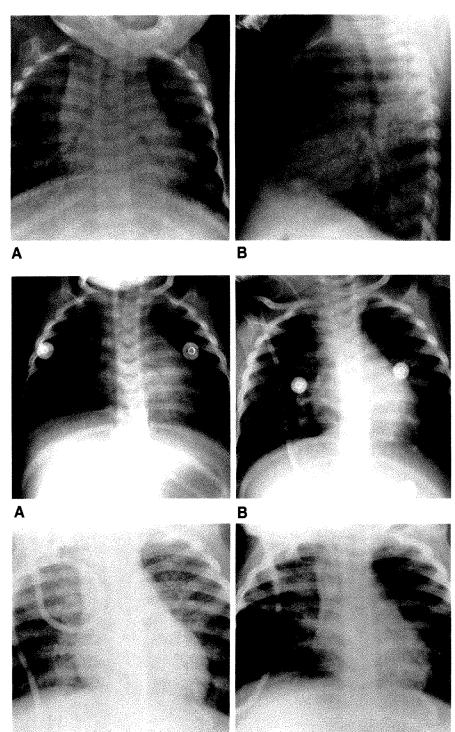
Evolution of radiographic changes in lymphocytic interstitial pneumonitis. Serial films at 2-month intervals in 16-month-old girl with AIDS.
